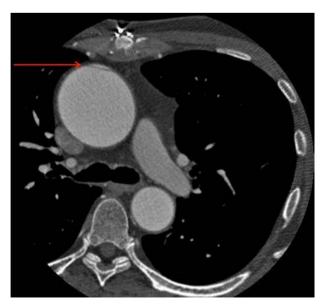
Cross-sectional CT image of ascending thoracic aneurysm with associated dissection flap (red arrow indicates dissection flap).
